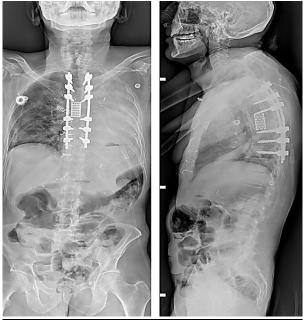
Postoperative standing full-spine X-ray showing the adequate position of the implants and kyphosis reduction
